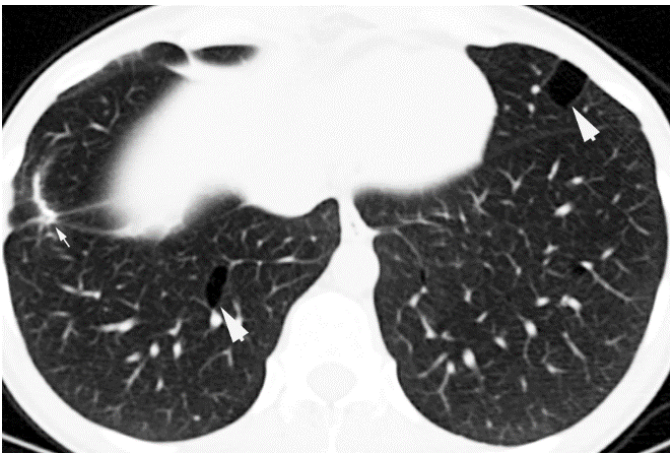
Lung CT scan performed following pulmonary consultation with us showing bilateral cystic changes. Cysts are various size, primarily localized in the lower lobe in the subpleural region. Large arrows are pointing cysts. The small arrow is pointing at lung resection surgery scar from 2 years before.
